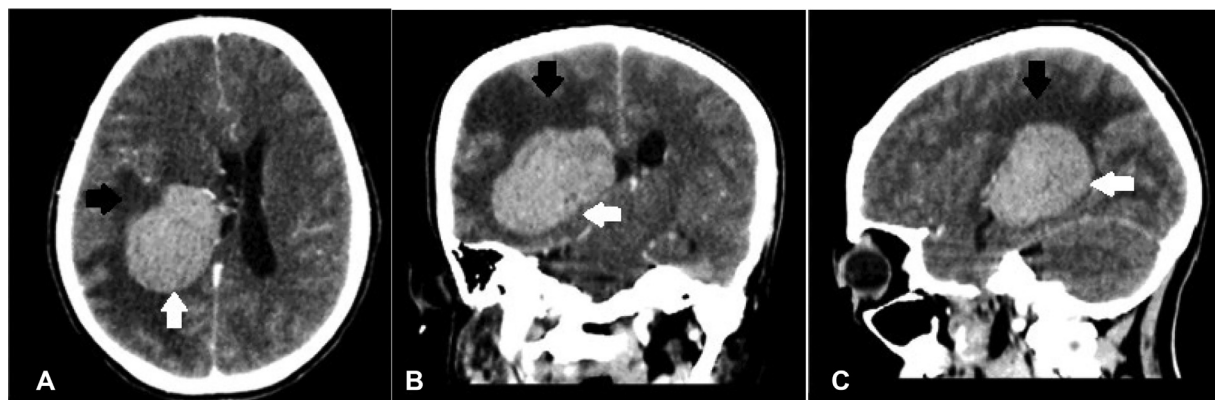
(A) CT contrast axial, (B) CT contrast coronal, and (C) CT contrast sagittal showed intense enhancement mass (white arrow) with vasogenic edema (black arrow).
